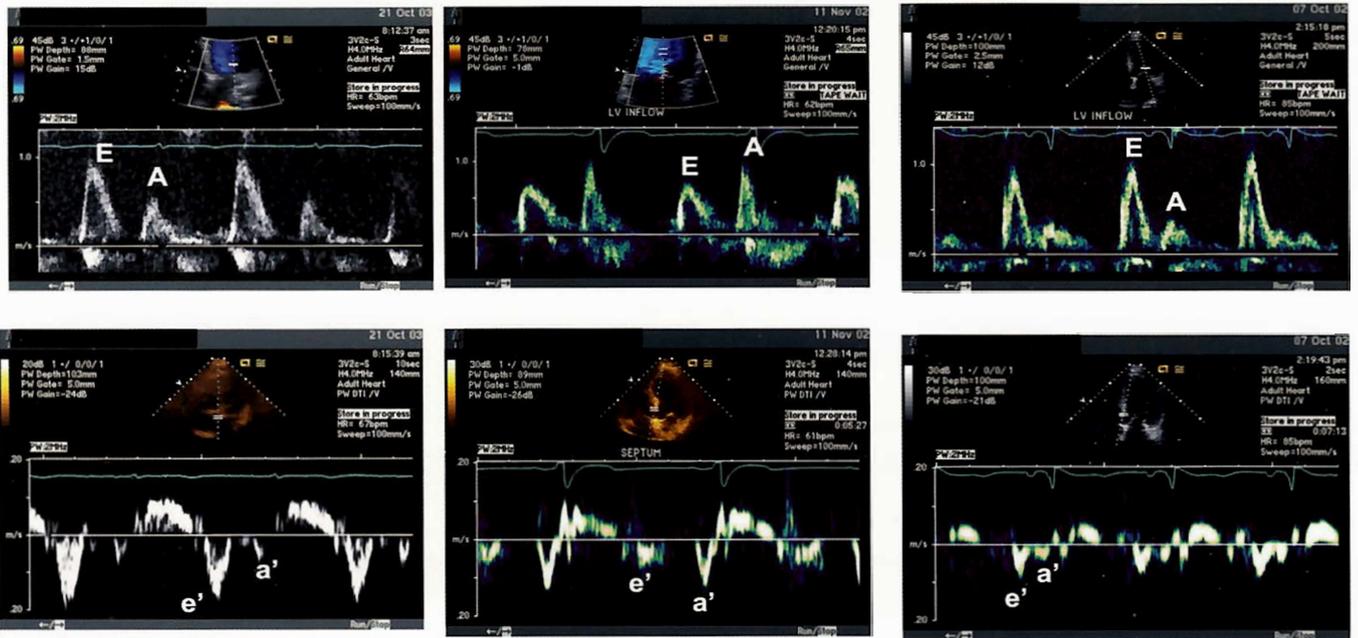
Upper panel shows mitral inflow velocity, and lower panel shows tissue Doppler (TD) derived mitral annulus velocities at the septal side of the annulus. The left panel of images is from a normal subject, the middle one was recorded from a patient with impaired relaxation, and the right one was obtained from a patient with restrictive LV filling. E stands for mitral early diastolic velocity, A stands for mitral late diastolic velocity, e' stands for mitral annulus early diastolic velocity by TD, and a' stands for mitral annulus late diastolic velocity by TD. The normal subject has an e' velocity of 18 cm/s, whereas e' is reduced in the other two patients. The reduced e' velocity signifies the presence of abnormal LV diastolic function.
